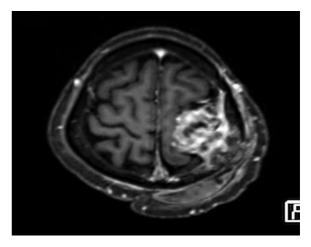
Postchemotherapy magnetic resonance imaging of the brain with contrast showing a hyperintense lesion in axial view (T1 postcontrast).
